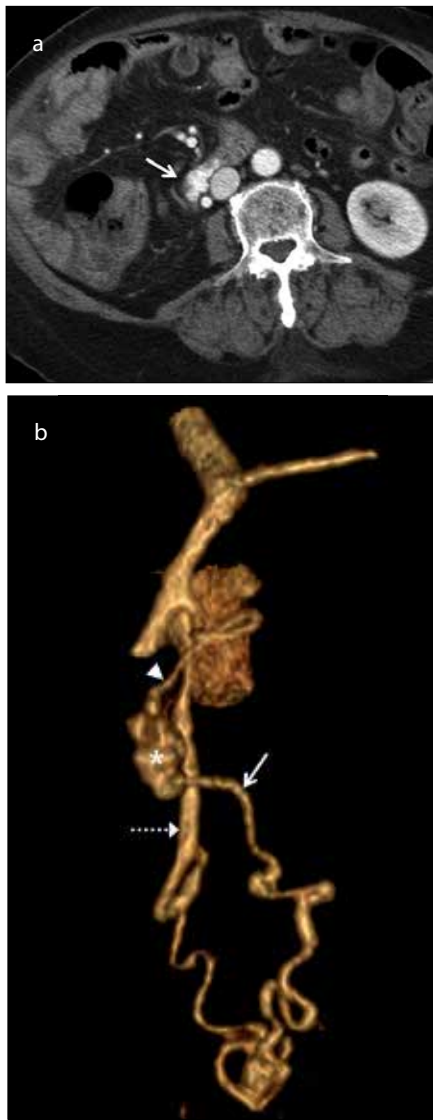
a, b. Axial contrast-enhanced CT scan (a) revealed markedly tortuous dilated veins (arrow) in the third portion of the duodenum. Volume-rendered image (b) demonstrated that the inferior pancreaticoduodenal vein (arrowhead) was the feeder of the duodenal varix (asterisk) and drained into the right ovarian vein (dashed arrow) via a tortuous efferent vein (arrow).
